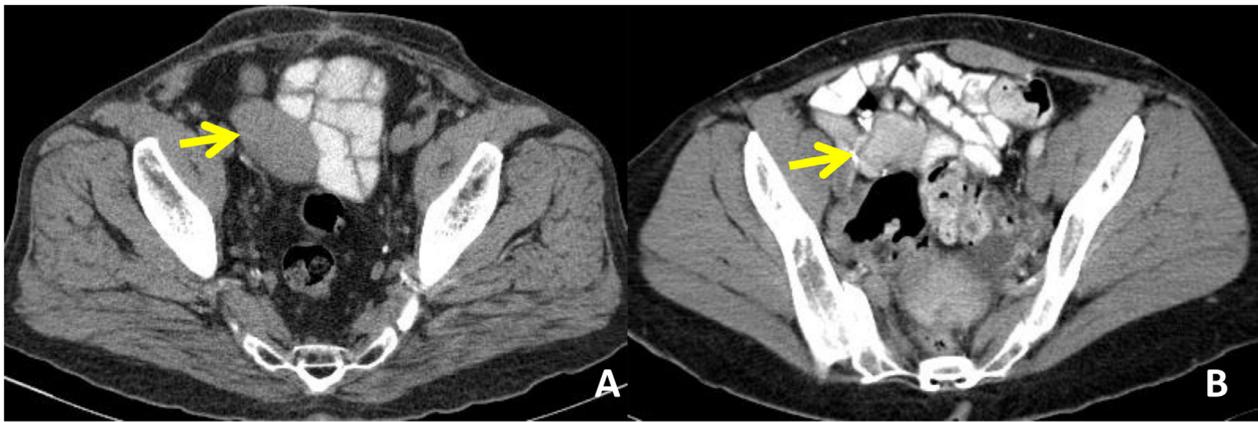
Image A shows a homogenous soft-tissue density structure in the right lower quadrant of the abdomen of a 56-year-old male, consistent with the non-contrast CT appearance of a pancreas transplant. Image B is of a 36-year-old female with a normal homogeneously enhancing pancreatic transplant in the right lower quadrant of the abdomen. Enteric contrast is noted in both images, in order to fully assess for bowel pathology. (Color version of figure is available online.)
